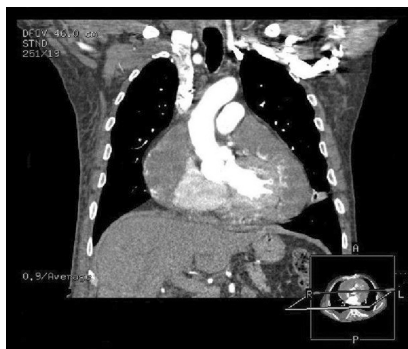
Computed tomography confirmed the presence of a heterogeneous mass containing necrotic tissue occupying the pericardial space and compromising both ventricles, the right atrium and superior and inferior cava veins.
